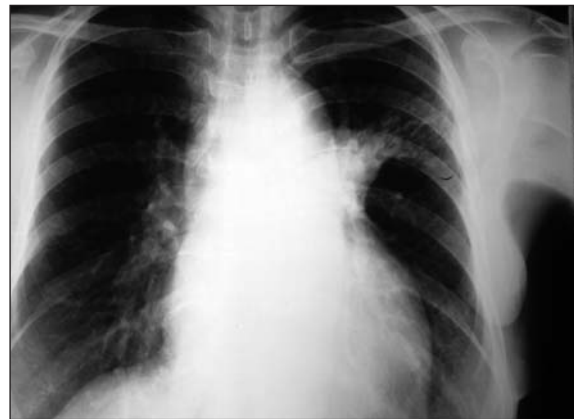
Plain chest X-ray shows left hilar mass like lesion with left upper lobe infiltrate mimicking tuberculosis.
